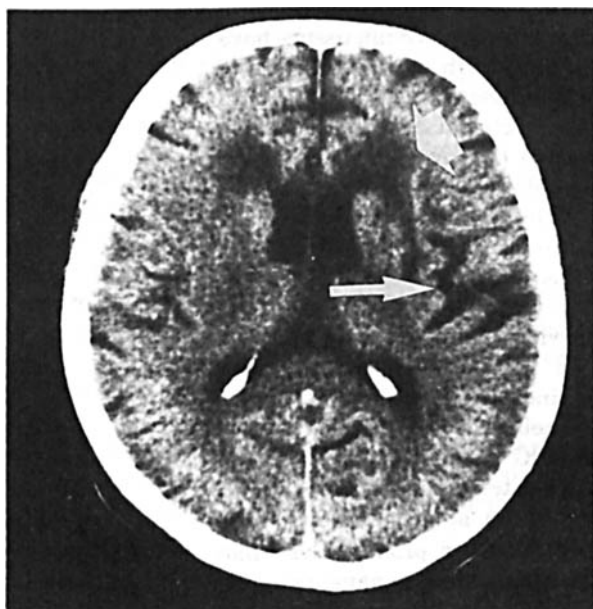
Cranial CT of patient 1: left frontal periventricular infarction (broad arrow), and left fronto-temporal cortical atrophy (slim arrow)
